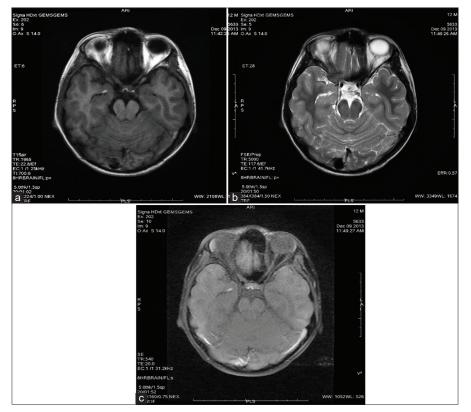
(a) Axial T1 W MRI brain showing a curvilinear hyperintense lesion in the right amygdala. (b) Axial T2 W MRI brain showing a curvilinear hyperintense lesion in the right amygdala. (c) Axial T1 fat-suppressed MRI brain showing a curvilinear hyperintense lesion in the right amygdala consistent with cerebral melanoma.
